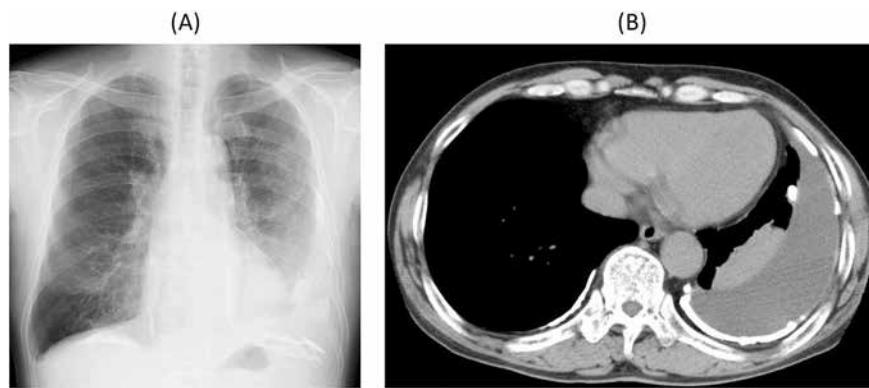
Left pleural effusion and calcified pleural plaques visible on chest X-ray (A) and computed tomographic (B) images.
